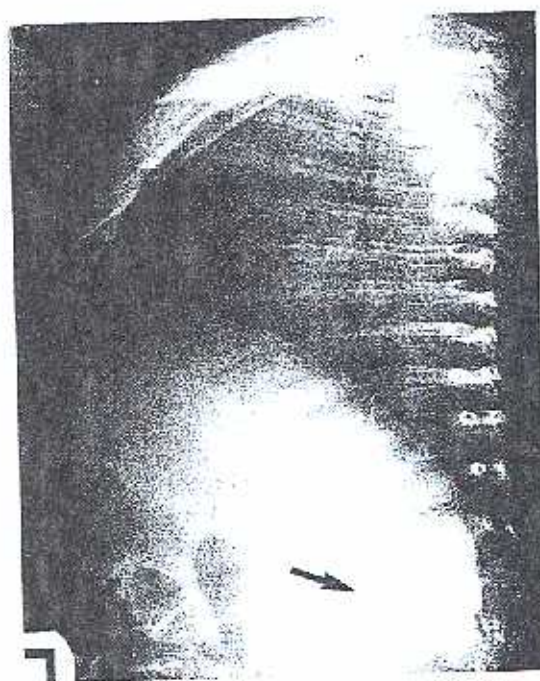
Lateral radiograph of abdomen showing bilateral adrenal calcifications.
